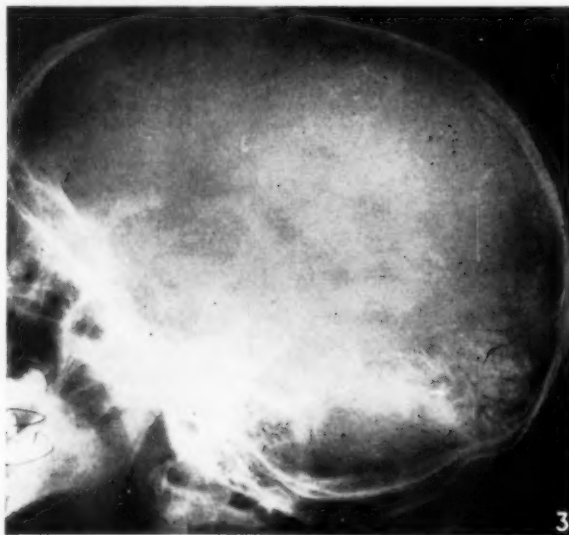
Lateral X-ray of skull showing massive calcification of a convoluted pattern in the region of the cerebellum.
